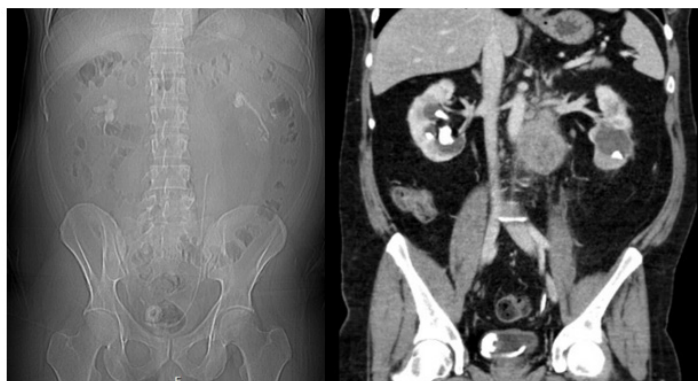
Computed tomography imaging of a retained stent.
